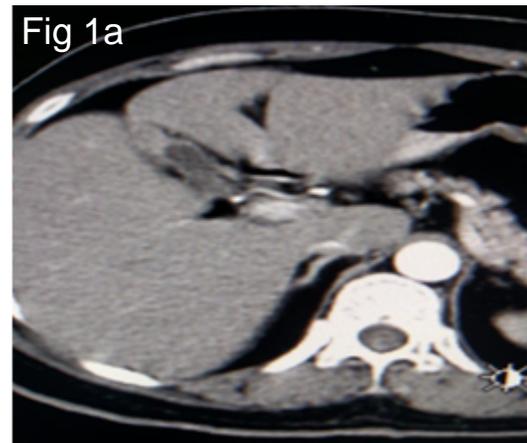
I a & b: CT scan abdomen showing accessory liver lobe as nodular structure
